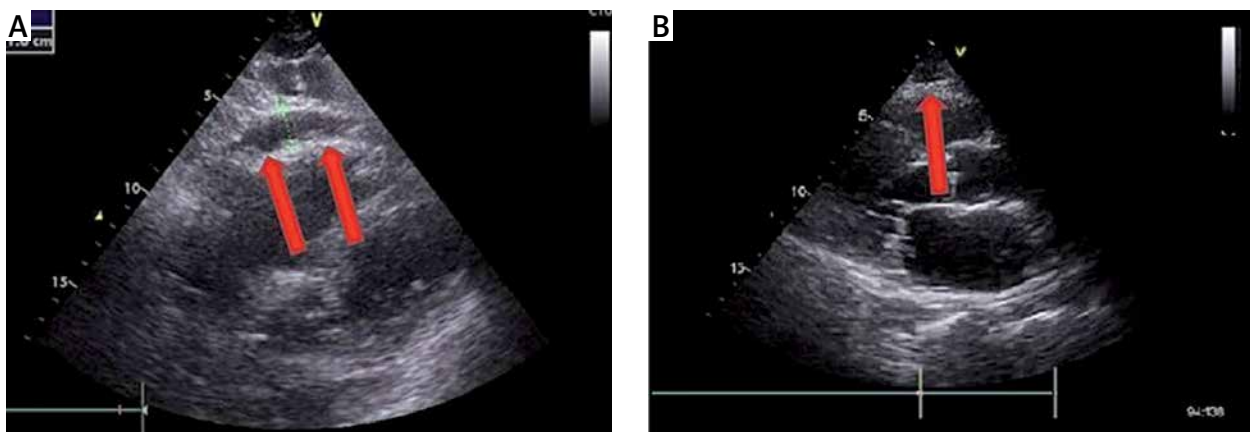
Transthoracic echocardiography. A – Subcostal view, fluid accumulation in pericardium after extravasation. B – Parasternal long axis view, assessment after the procedure, less than 5 mm of fluid in pericardium is seen
